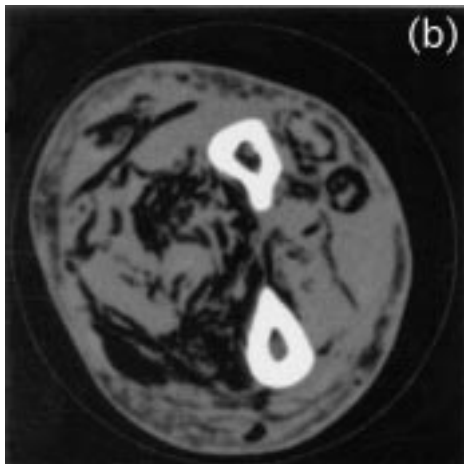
Clinical CT scan of same subject.
